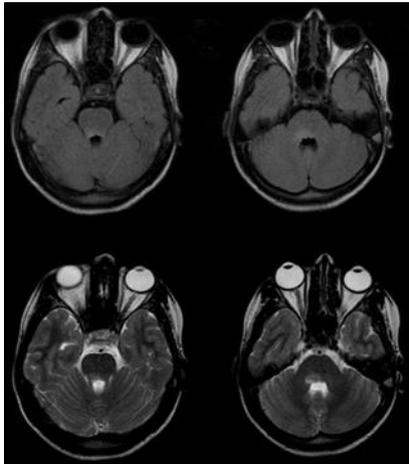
Brain stem involvement in multiple sclerosisFig 6: Axial T2/FLAIR images showing small, well defined hyperintensity in the tegmentum of pons in a known case of neuromyelitis optica
